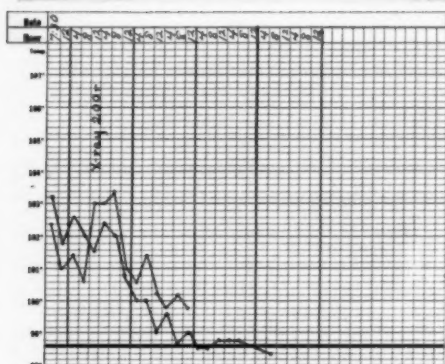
Acute lobar pneumococcal pneumonia; 200 roentgens to anterior chest second hospital day. Prompt response. Temperature decline by rapid lysis. Complete recovery.
